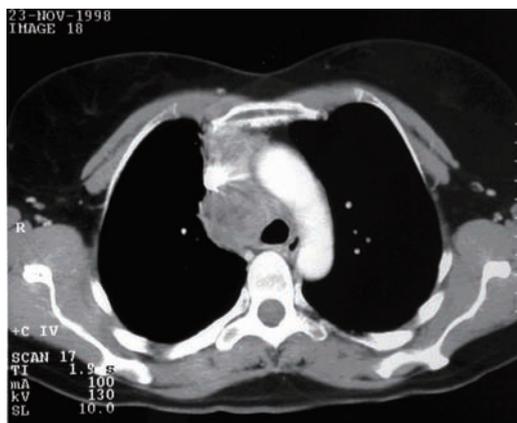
Chest CT scan demonstrating bulky N2 disease
